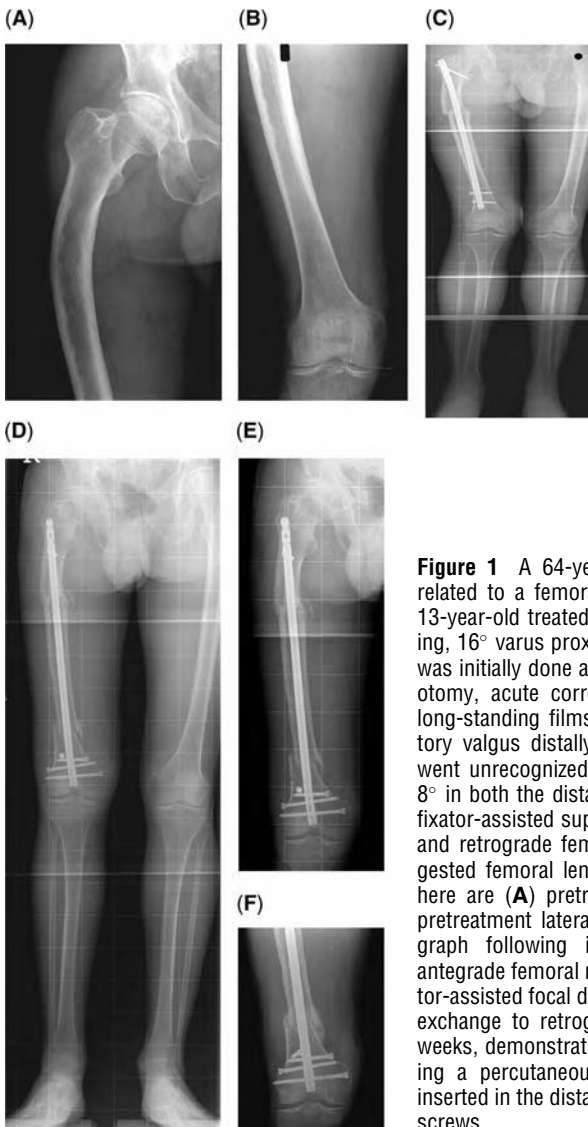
A 64-year-old man developed chronic hip and knee pain related to a femoral malunion resulting from a fractured femur as a 13-year-old treated in traction. The deformities included 3 cm shortening, 16° varus proximal femur, and 15° internal rotation. The treatment was initially done at another institution through a subtrochanteric osteotomy, acute correction, and antegrade femoral nail. Unfortunately, long-standing films were not obtained preoperatively, and compensatory valgus distally that had developed during his remaining growth went unrecognized. He presented with a residual valgus deformity of 8° in both the distal femur and proximal tibia. This was treated with a fixator-assisted supracondylar focal dome osteotomy, acute correction, and retrograde femoral nail. Given the age, the person declined suggested femoral lengthening to equalize the limb lengths. Reproduced here are (A) pretreatment anteroposterior (AP) proximal femur; (B) pretreatment lateral proximal femur radiographs; (C) erect leg radiograph following initial corrective subtrochanteric osteotomy and antegrade femoral nail; (D) erect leg; (E) AP radiographs following fixator-assisted focal dome supracondylar osteotomy, acute correction, and exchange to retrograde femoral nail; and (F) AP radiograph at nine weeks, demonstrating bridging callus and typical of rapid union following a percutaneous osteotomy. Note the use of a blocking screw inserted in the distal fragment immediately proximal to the three locking screws.
